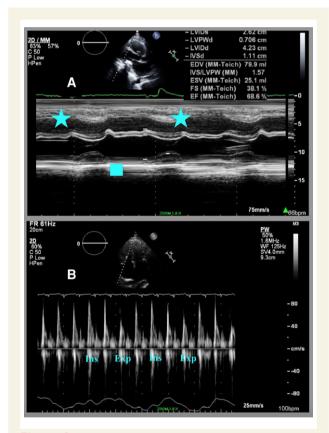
(A) Transthoracic echocardiogram M-mode showing diastolic inferolateral wall flattening and septal bounce. (B) Transthoracic echocardiogram Doppler showing atrioventricular valve respiratory variation.
